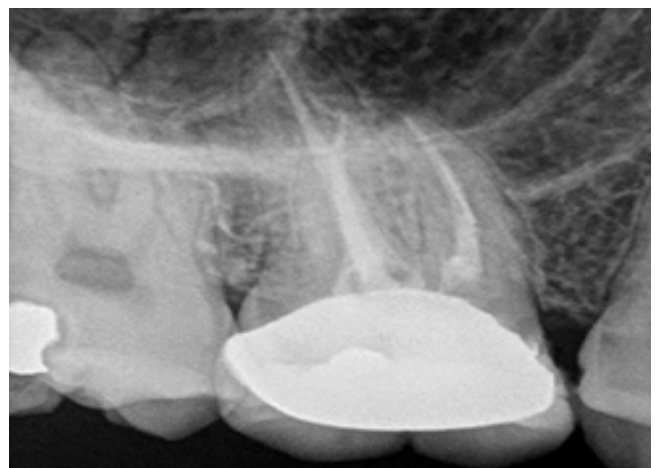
Radiograph taken during 12 month follow up
